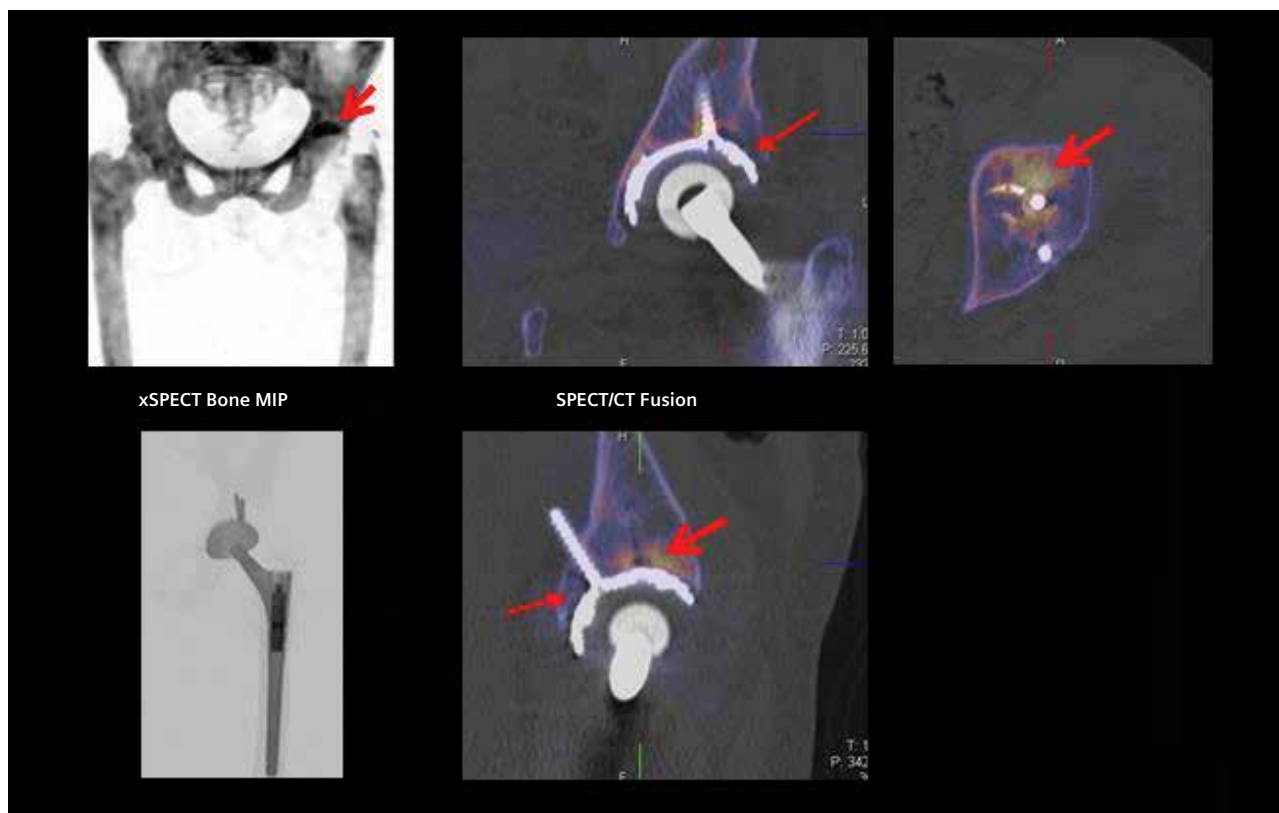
SPECT MIP image shows focal area of increased uptake in the left acetabulum (bold red arrow). Fused xSPECT images show zones of osteolysis and lucency bordering the acetabular cup (thin red arrows). Areas of osteolysis and increased uptake of tracer around the acetabular screw (bold red arrow on fused images) reflect loosening related to periprosthetic bone stress.
